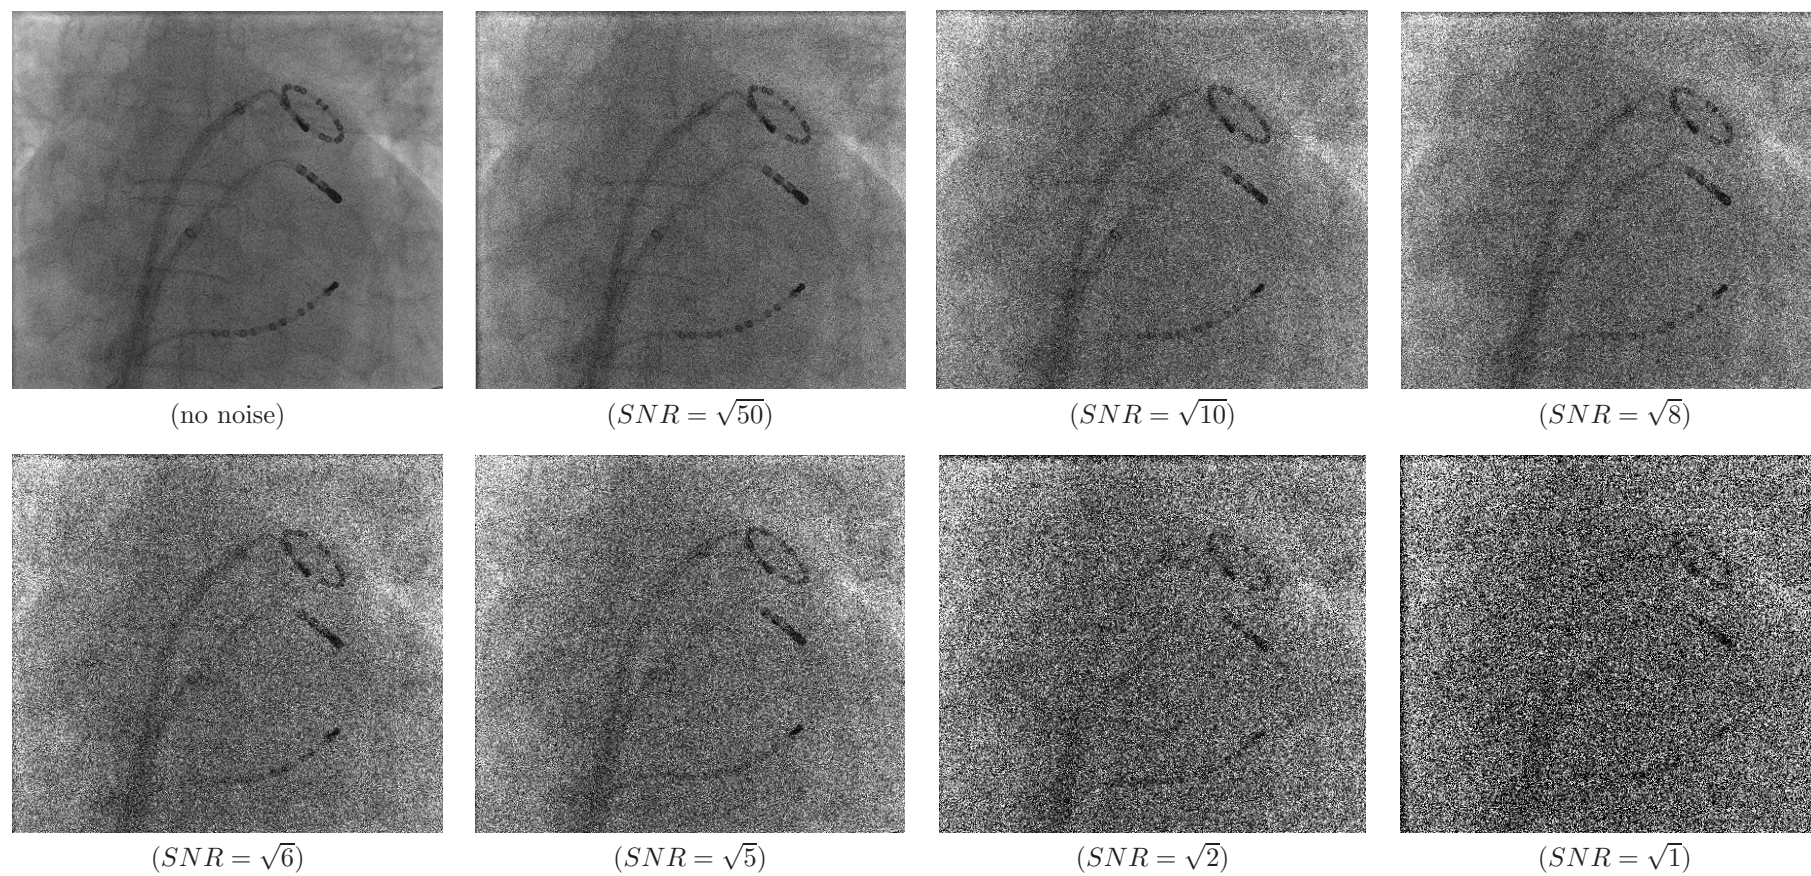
(a) Case 1: Example of an uncorrupted RFA clinical X-ray image; (b-h) the same X-ray image corrupted with different levels of Poisson noise.
